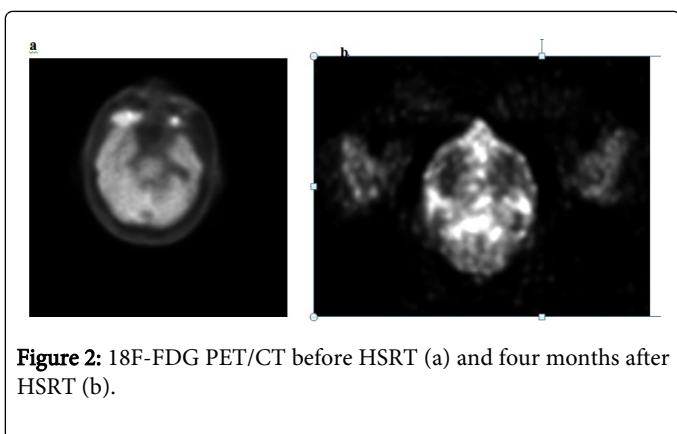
18F-FDG PET/CT before HSRT (a) and four months after HSRT (b).
